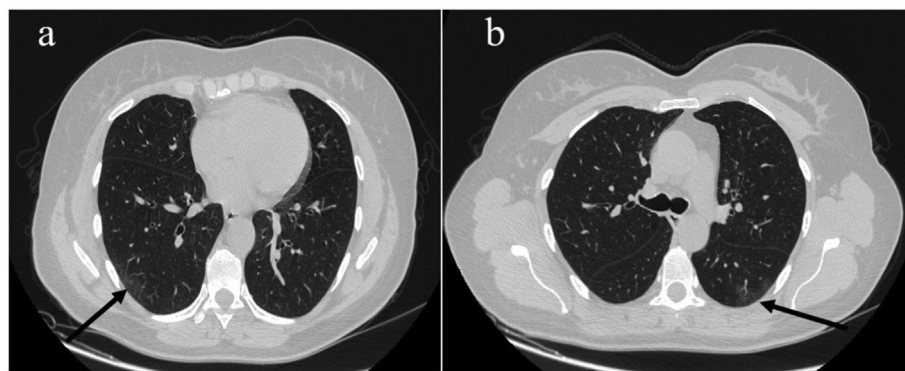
Images a,b describe some GGOs (black arrows) with the typical peripheral distribution in the inferior lobes on the chest CT scan of the second patient.
